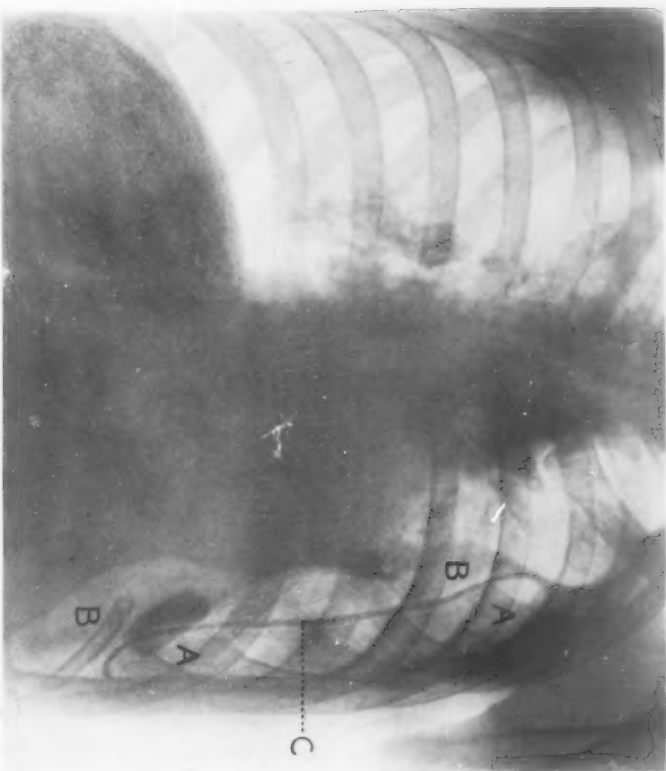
A tuberculous empyemic cavity in which an attempt was made to substitute a sterile extrapleural cavity for a septic intrapleural cavity by stripping the parietal pleura. (See text, Method 2.) The result, due to the thickness and rigidity of the parietal pleura, was a partial and not a total obliteration of the intrapleural cavity. A, extrapleural cavity; B, intrapleural cavity; C, the mobilized parietal pleura. (X-ray taken about ten days after operation.)
